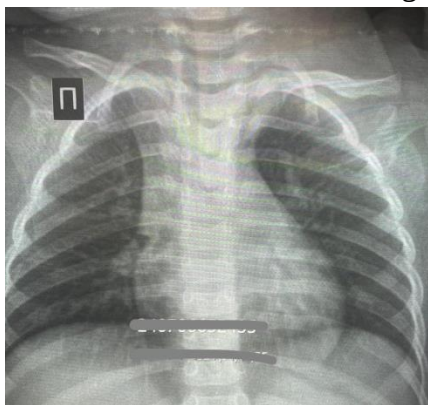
In Patient No. 5, no radiographic evidence of pneumonia was observed on the chest radiograph on day 1 of illness.
